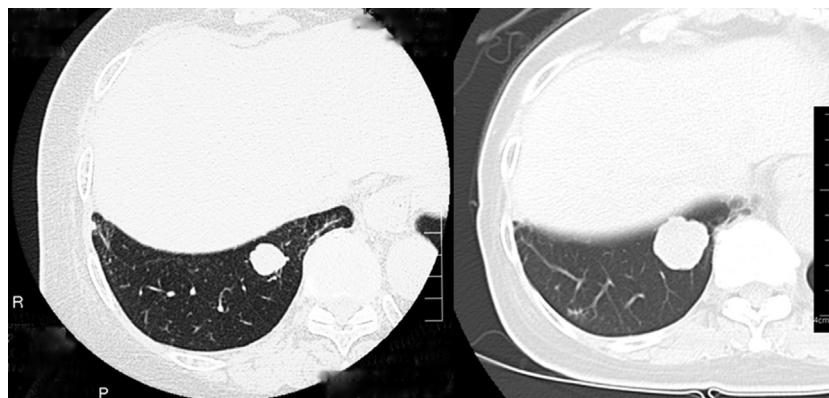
Chest CT scan showing a well-demarcated nodule in the right lower lung field. The nodule has grown very slowly (left, an 18-mm nodule in 2007; right a 27.5-mm nodule in 2015).
